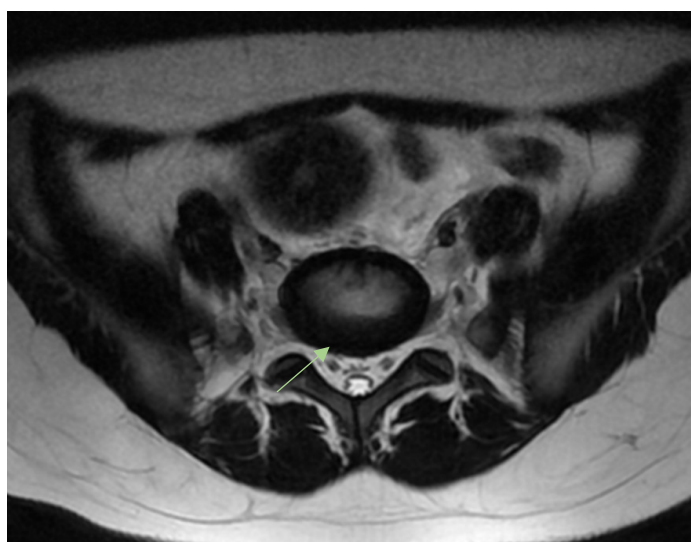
First MRI of the lumbar spine T2 AXIAL
